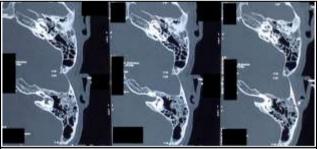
HRCT Scan of Temporal Bone Showing Longitudinal Fracture Extending into Proximal Tympanic Portion of Facial Nerve Canal, Anterior Wall of External Auditory Canal, Tegmen Tympani, Carotid Canal and Petrous Apex with Mild Subluxation of Incudo-Malleal Joint
